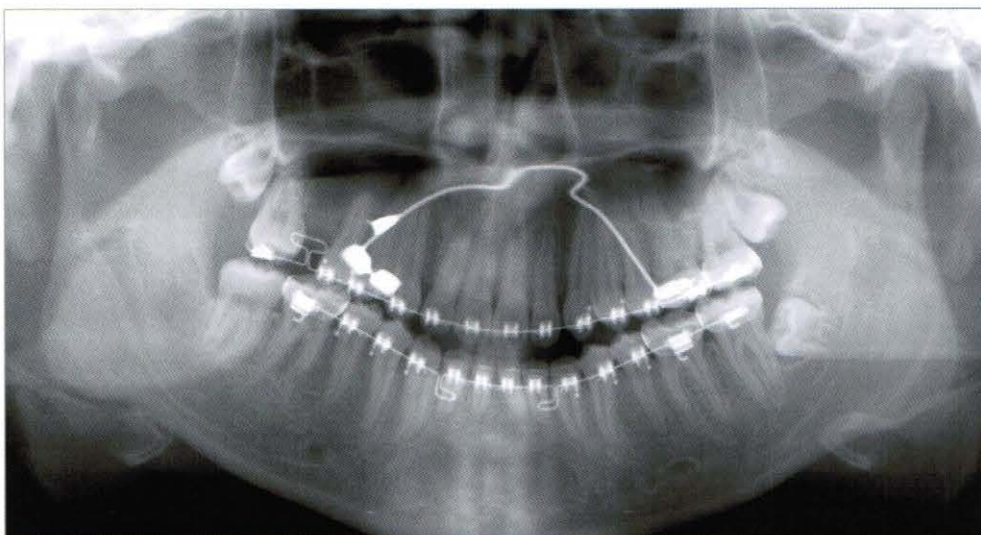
Panoramic radiograph after mesial protraction of upper right second molar (2005, 1,19)
